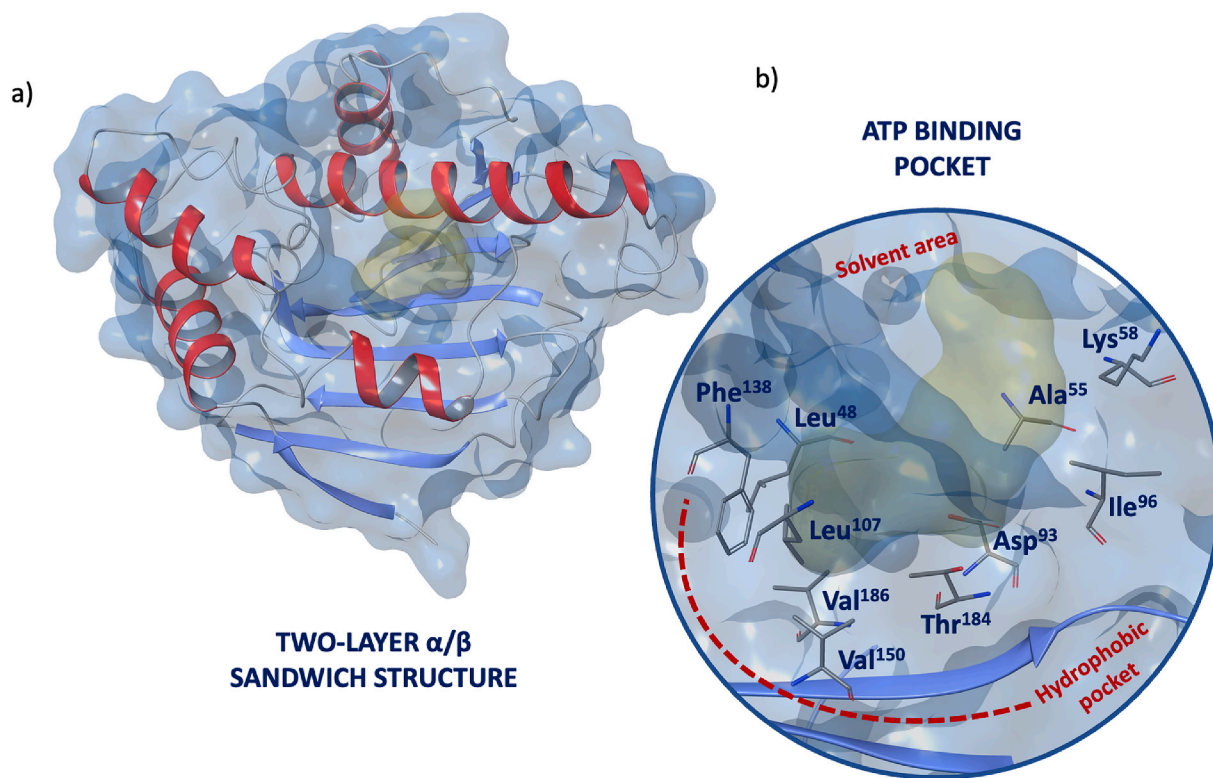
(a) X-Ray structure of two-layer α/β sandwich structure of HSP90 ATP binding pocket (PDB ID: 5GGZ) [27]; (b) focus on the ATP binding site, highlighting key conserved functional residues of the hydrophobic pocket and the solvent area (PDB ID: 5GGZ) [27].
